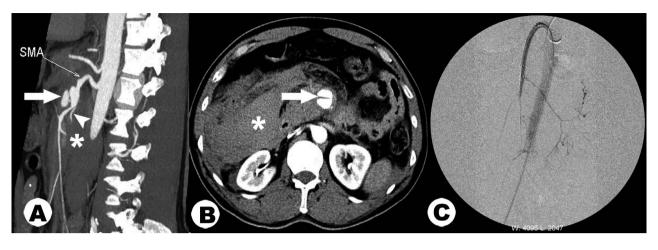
(A) Sagittal imaging and (B) axial imaging. Computed tomography angiography showing a ruptured aneurysm of the superior mesenteric artery (arrow) with a huge retroperitoneal hematoma (asterisk) and a small branch originating from the region of the aneurysm (arrowhead). (C) Angiogram after stent graft implantation.
